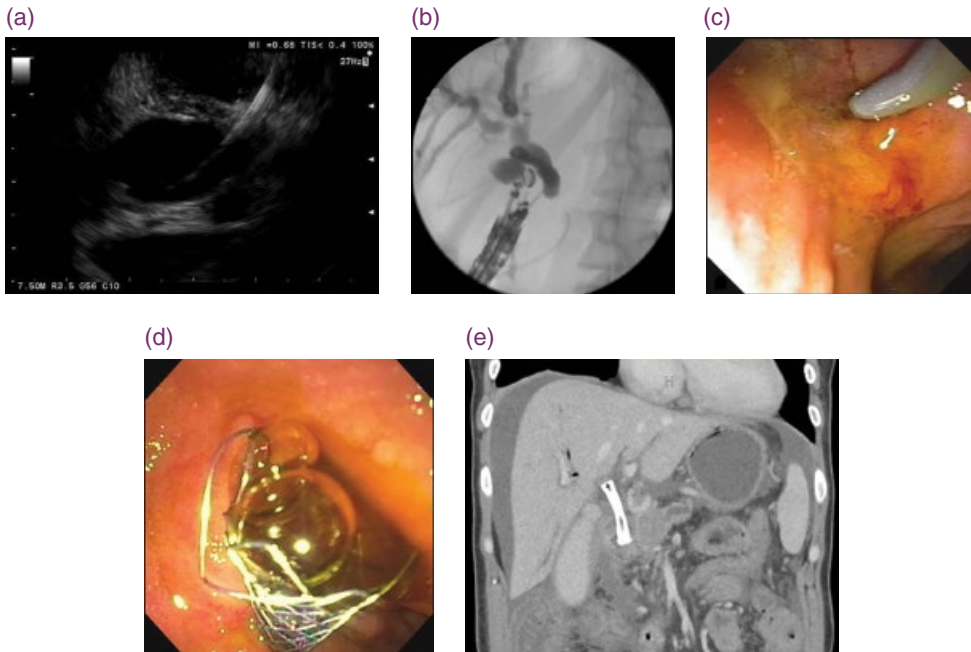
Endoscopic ultrasound guided biliary drainage (EGBD) using the direct transluminal technique. (a) Endosonographic image showing the needle and guidewire within the common bile duct (CBD). (b) Antegrade cholangiography demonstrating intra- and extrahepatic biliary dilation with an abrupt cut-off in the mid CBD. A prophylactic pancreatic stent placed at failed endoscopic retrograde cholangiopancreatography remains in situ. (c) The choledochoduodenostomy (CDS) was dilated with a dilating bougie catheter (4–7 Fr). (d) A large volume of bile flowing through the fully covered self-expanding metallic biliary stent that was placed across the CDS. (e) A coronal computed tomography image 4 weeks after EGBD reveals an optimal stent position and absence of biliary ductal dilation.
